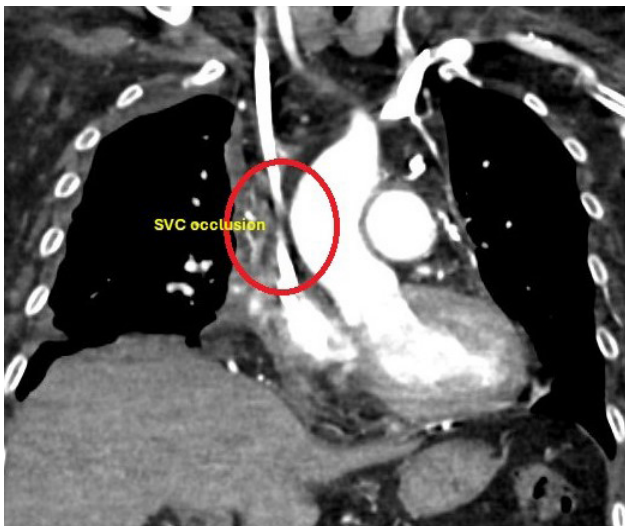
CT scan demonstrating SVC occlusion. Abbreviation: SVC, superior vena cava.
